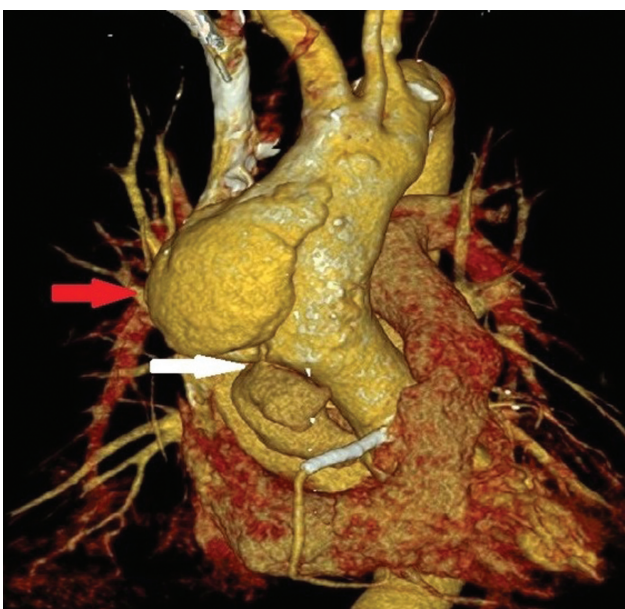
Computed tomographic reconstruction of contained rupture of the ascending aorta approximately 5 cm above the aortic annulus (white arrow) and aneurysmatic ascending aorta distally (red arrow).
